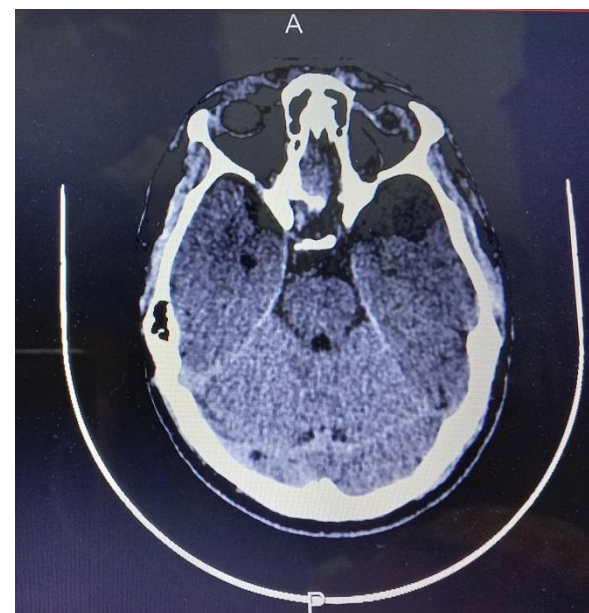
Axial view of Computed Tomography Scan of Arachnoid cyst seen at left temporal lobe.
